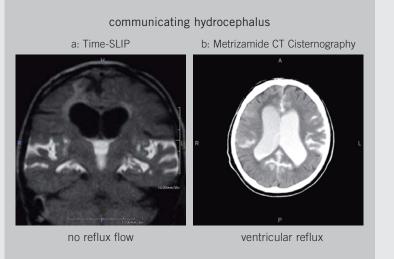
Images of Communicating Hydrocephalus by Time-SLIP (a) and Metrizamide CT Cisternography (b)
